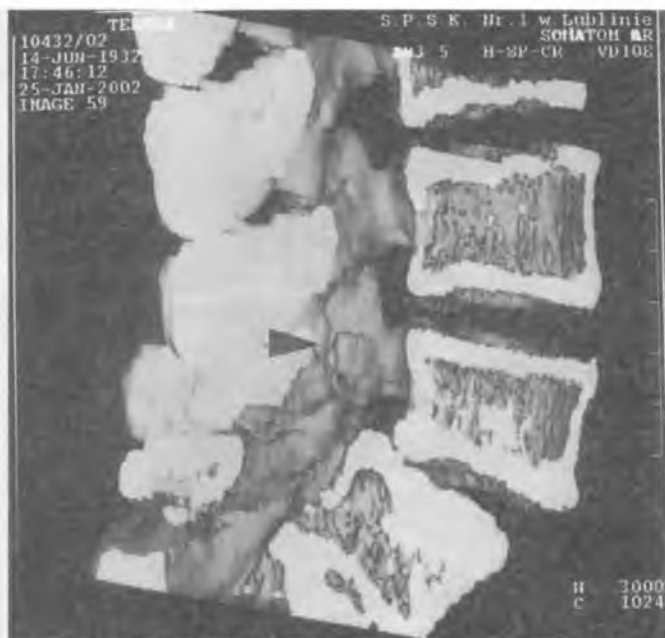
Degree I slip – 3D CT shows a break in the continuity of L5 arch (arrow)
